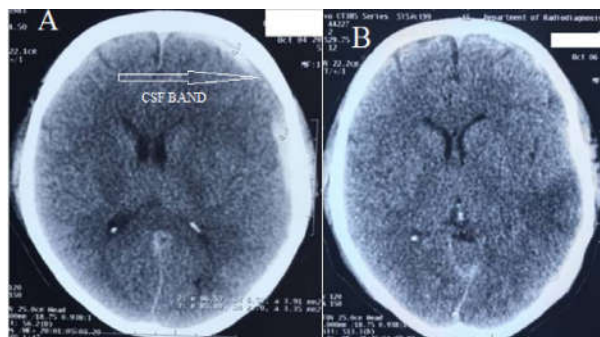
Case no.3 (A) initial CT head showing left side acute SDH and CSF band (arrow), (B) Repeat CT head of same patient having spontaneous resolution of SDH
